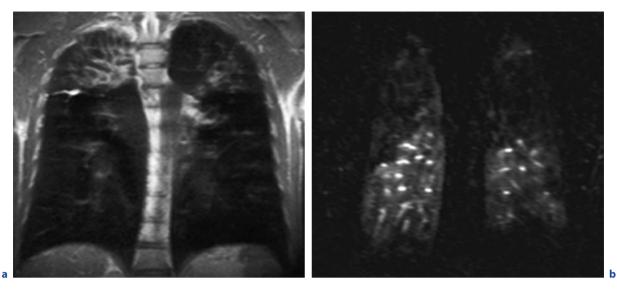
a T2 weighted MR image of the patient shown in Fig 10.2 showing lobar destruction of the right upper lobe and severe bronchiectasis and wall thickening of the left lobe. b MR-Perfusion map of the corresponding lung region showing large perfusion defects in both upper lobes and an inhomogeneous perfusion in the peripheral lower lobe zones. (Reprint with permisson. Altes TA, Eichinger M, Puderbach M (2007) Magnetic Resonance Imaging of the Lung in Cystic Fibrosis. Proceedings of the American Thoracic Society 4:322–325)
